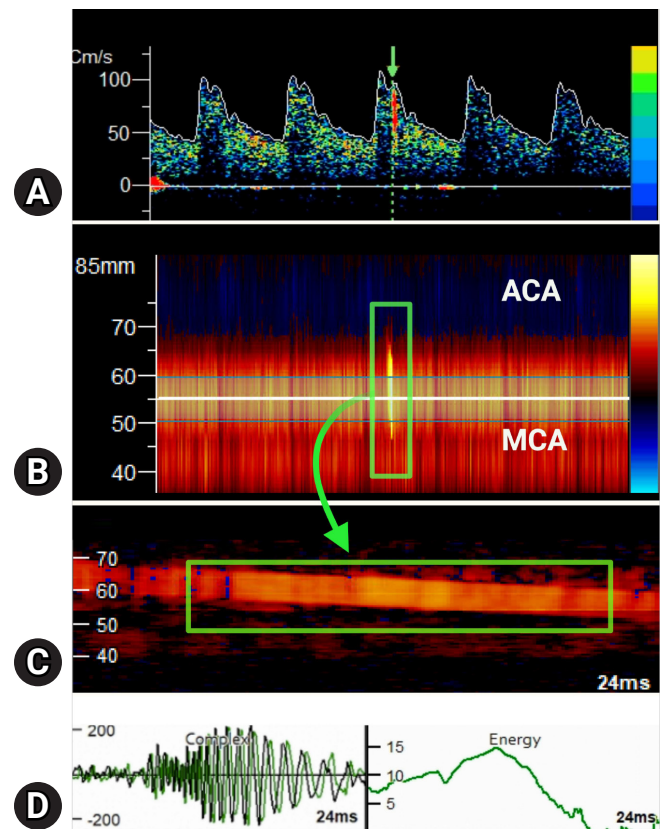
Transcranial Doppler ultrasound (Viasonix Dolphin/XF, Imaging Monitoring USA) results. (A) Transcranial Doppler spectral waveform of the left middle cerebral artery (MCA) obtained via transtemporal approach with a high-intensity transient signal (HITS) noted (arrow). (B) Power M-mode with a red band extending from 35 to 65 mm denoting anterograde blood flow in the MCA and a blue band extending from 65 to 75 mm denoting retrograde flow in the anterior cerebral artery (ACA). Note the HITS in green box, which is brief (<0.3 seconds) and unidirectional (slightly negatively slanted orientation, reflecting movement towards probe over time as blood flows laterally through MCA). (C) High-resolution M-mode allows further characterization of HITS (green box) at 24 msec resolution to confirm that the signal is unidirectional along its entire length, increasing the likelihood that it reflects true microemboli and is not an artifact (D) Complex velocity analysis demonstrates matching Doppler shift frequencies for HITS (green waveform) and blood flow (black waveform) suggesting that both are in-phase, increasing the likelihood of a true embolic signature rather than an artifact. Energy measurement showing that the event is of sufficiently high intensity (15 dB) to be consistent with microembolic signal.
